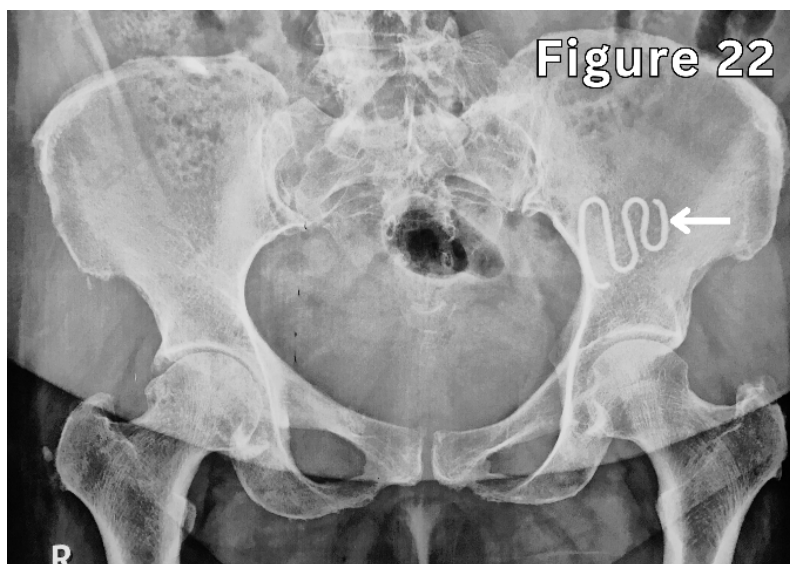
Pelvic X-ray showing a displaced intrauterine contraceptive device (Lippes loop), with migration from the uterus to the left side of the pelvis.
